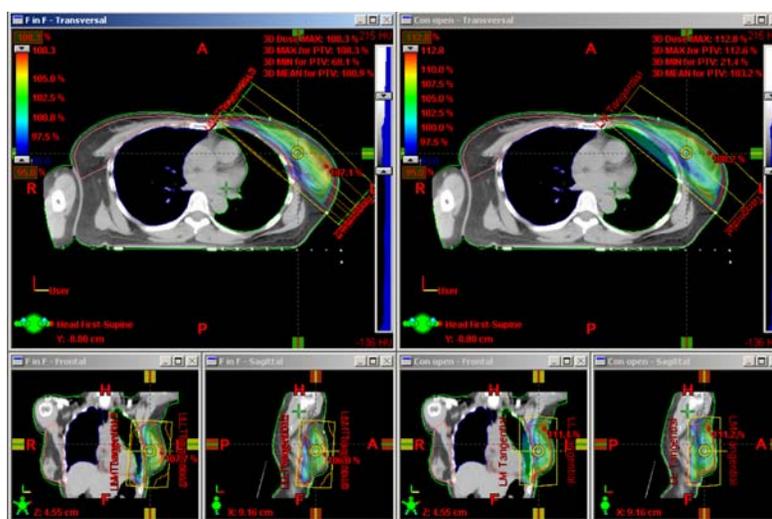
Isodose distributions in color wash for conventional and fIMRT plan. Data are shown on the same CT slice for one representative patient. Distributions are similar for all other patients
